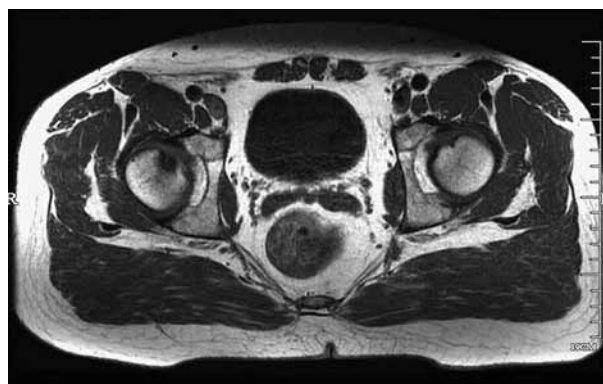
Pre-operative MRI of the pelvis, axial view. Osteochondral lesion of the right femoral head clearly visible as a defect on the articular side.
